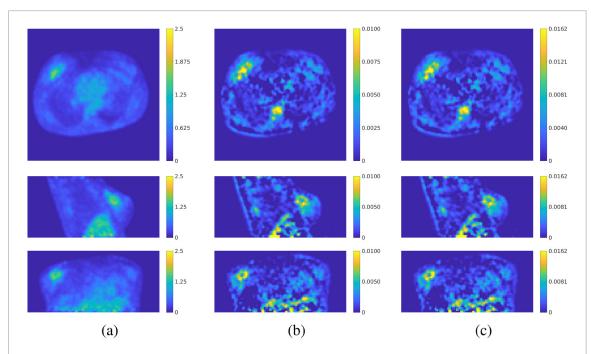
Comparison of SUV images and parametric imaging using the standard Patlak plot and relative Patlak plot for the breast patient. (a) SUV images; (b) parametric image of the standard Patlak slope K_i ; (c) parametric image of the relative Patlak slope K_i . The start time $t^* = 30$ min. From the top to the bottom are the views from the planes of transverse, sagittal and coronal, respectively.
